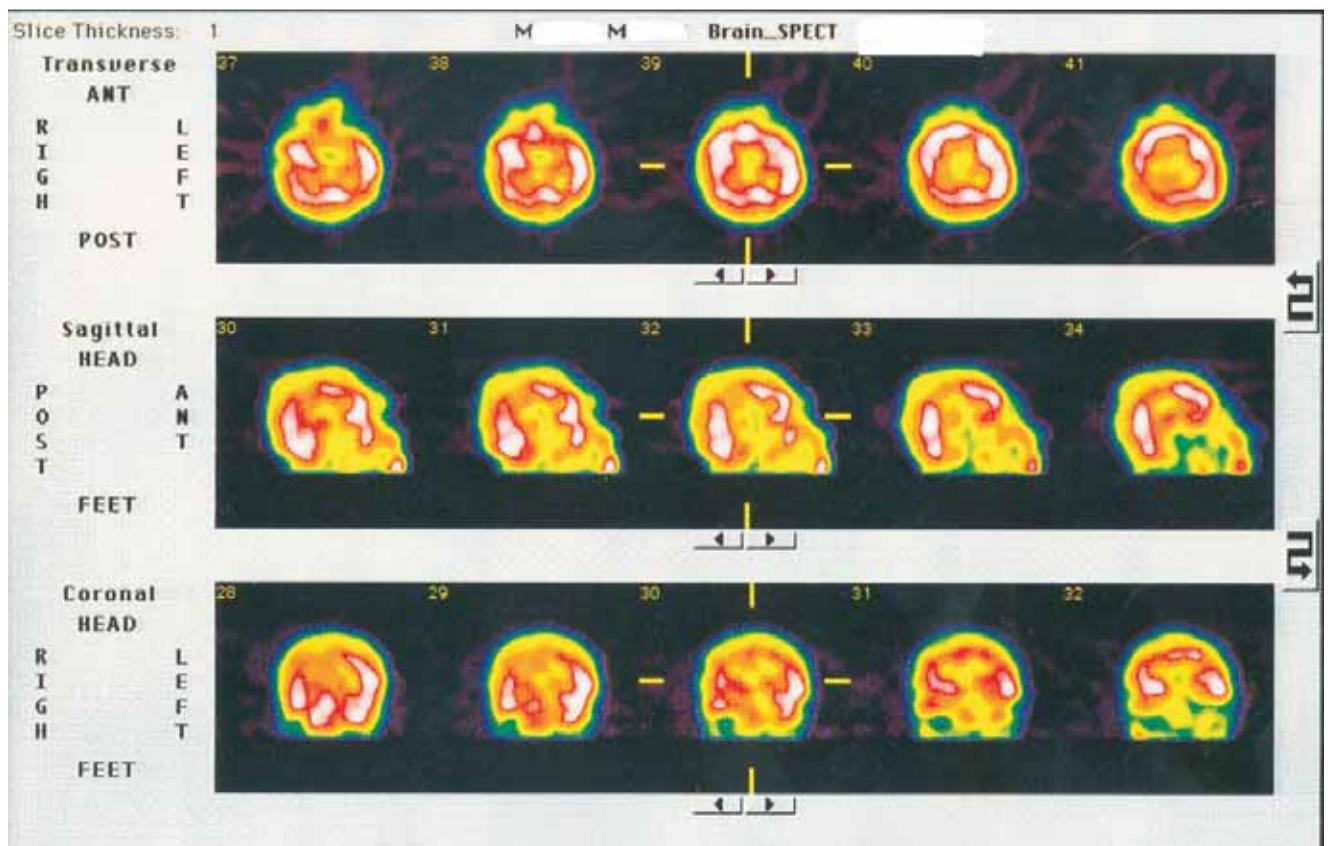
Cerebral mTC-HMPAO SPECT – no anomalies of cerebral blood flow
